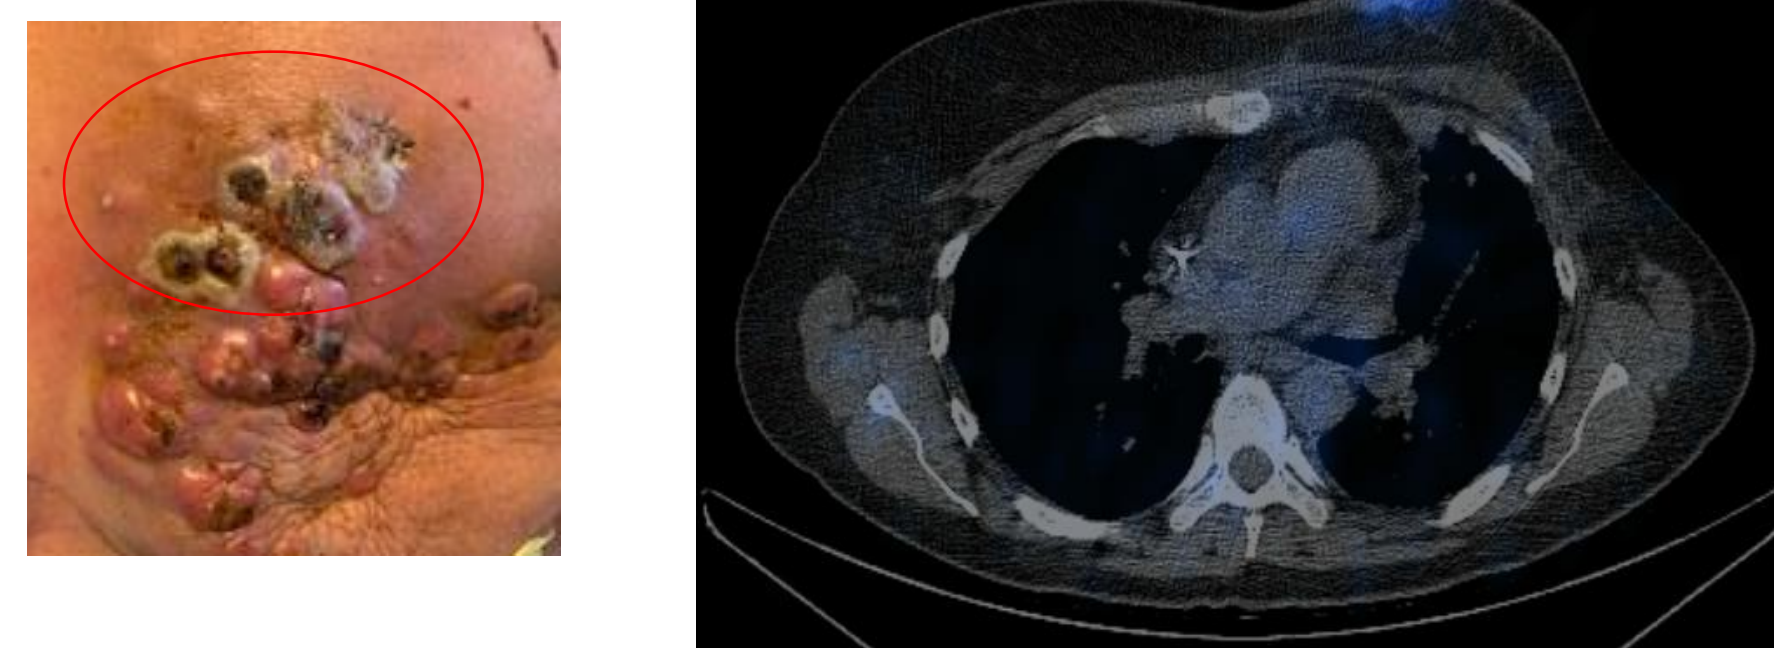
SPECT imaging using Technetium-99m.
